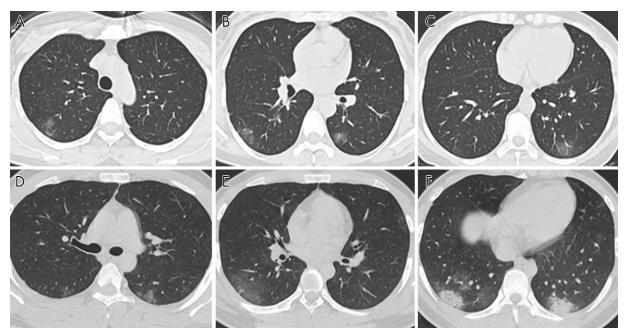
A-C, Noncontrast chest CT images in a 46-year-old woman with mild COVID-19 pneumonia. CT images show ground-glass opacities in the posterior segment of right upper lobe, superior segment of bilateral lungs, and posterior basal segment of right left lobe, and the CT-SS is 4. D-F, Noncontrast chest CT images in a 20-year-old man with mild COVID-19 pneumonia. CT images show ground-glass opacities and consolidation in multiple lung segments, and the CT-SS is 7.
